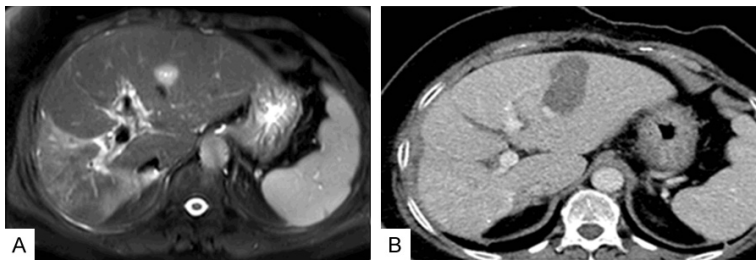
Radiological view of the tumor. A. Segment 2 metastatic tumor in MR before ablation. B. CT image 1 week after ablation. The tumor appears to be totally ablated.
